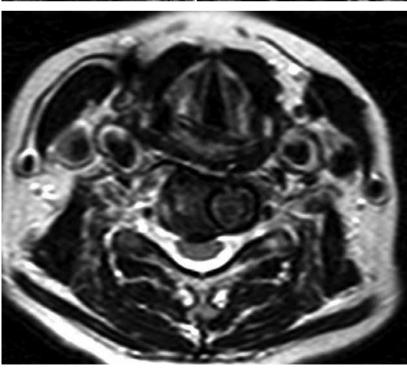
MRI, transverse section, after the injury.
